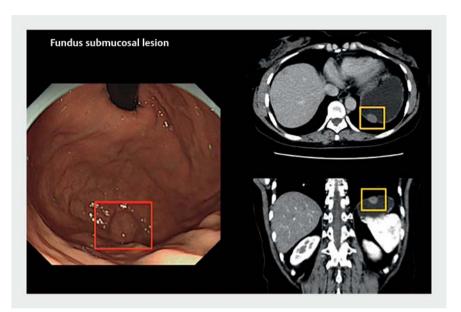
Endoscopic view and computed tomography images of a gastric stromal tumor in the fundus of stomach.
